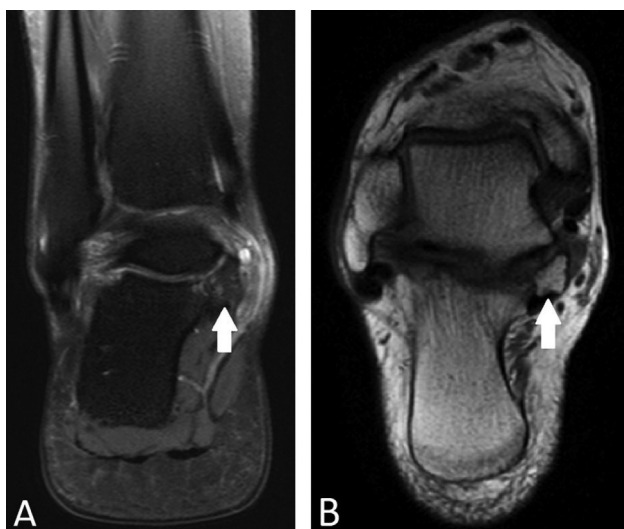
MRI of the right ankle in the coronal section in the T2 FAT SAT sequence in A and coronal oblique in the T1 sequence in B demonstrating a talocalcaneal coalition with *Os sustentaculum*, with foci of edema associated (white arrows).
